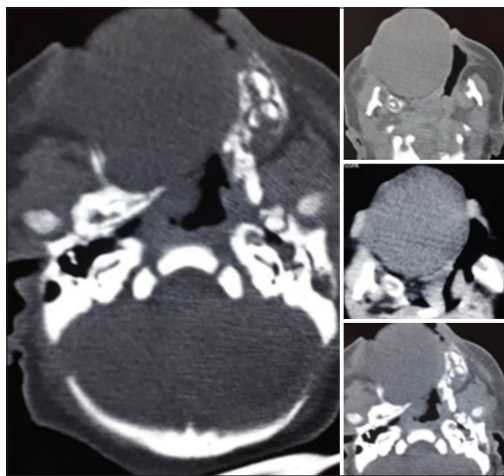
Computed tomography neck showed cystic hypodense lesion measuring 4.9 cm × 4.3 cm × 4.6 cm within the oral cavity in its anterior aspect
